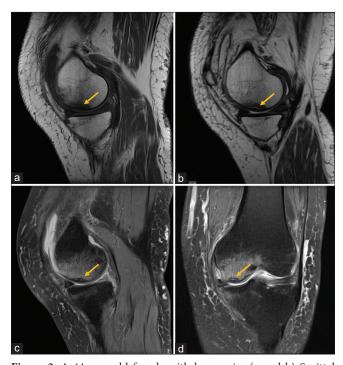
A 44-year-old female with knee pain. (a and b) Sagittal T1- and T2-weighted images show subchondral fracture (arrows) parallel to the cortex involving the medial femoral condyle. (c and d) Corresponding sagittal and coronal STIR images show subchondral fracture (arrows) with surrounding hyperintense edema.
